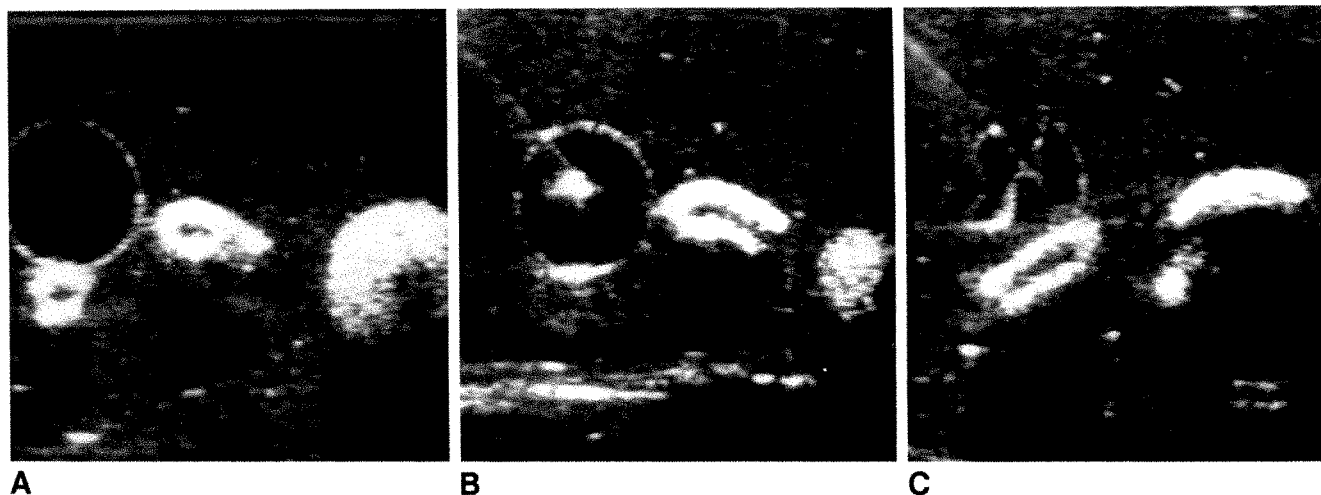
A, Sonogram shows elbow macaroni and a diced carrot. Fluid-filled tip of a surgical glove gives appearance of a cyst. B, Sonogram shows "cyst" punctured under guidance by using a 22-gauge needle with echogenic tip. C, "Cyst" has been partially evacuated. Needle is still in place.
